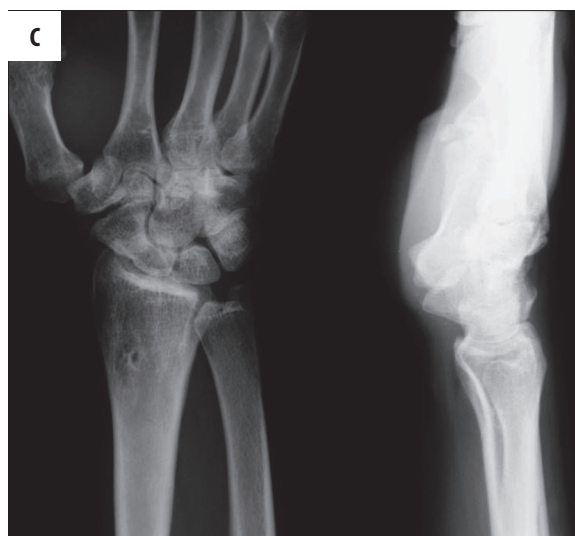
(A) Radiographic view of scaphoid non-union. (B) Two months post-operatively. (C) Four and half years post-operatively.
